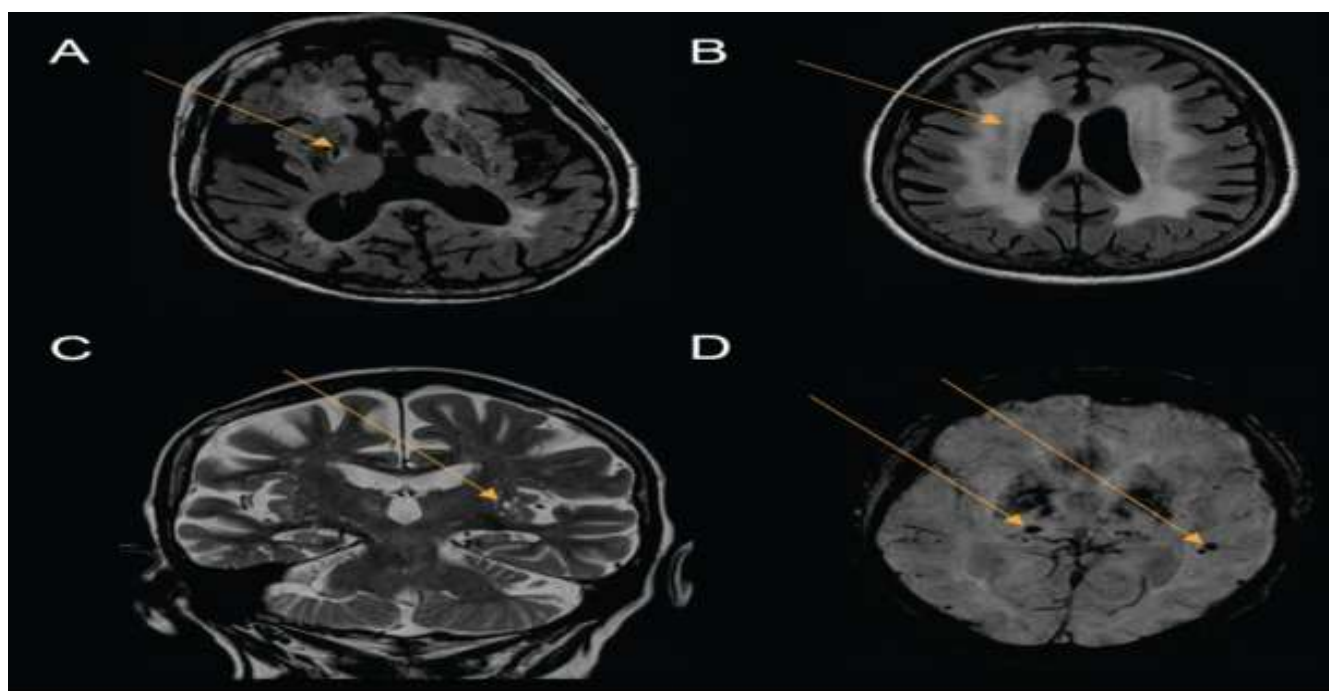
A) FLAIR T2WI MRI, chronic lacunar infarction (low intensity lesion with hyperintense rim of gliosis in the right lobe basal ganglia) B) FLAIR T2WI MRI, degeneration and gliosis of the white matter appear as
